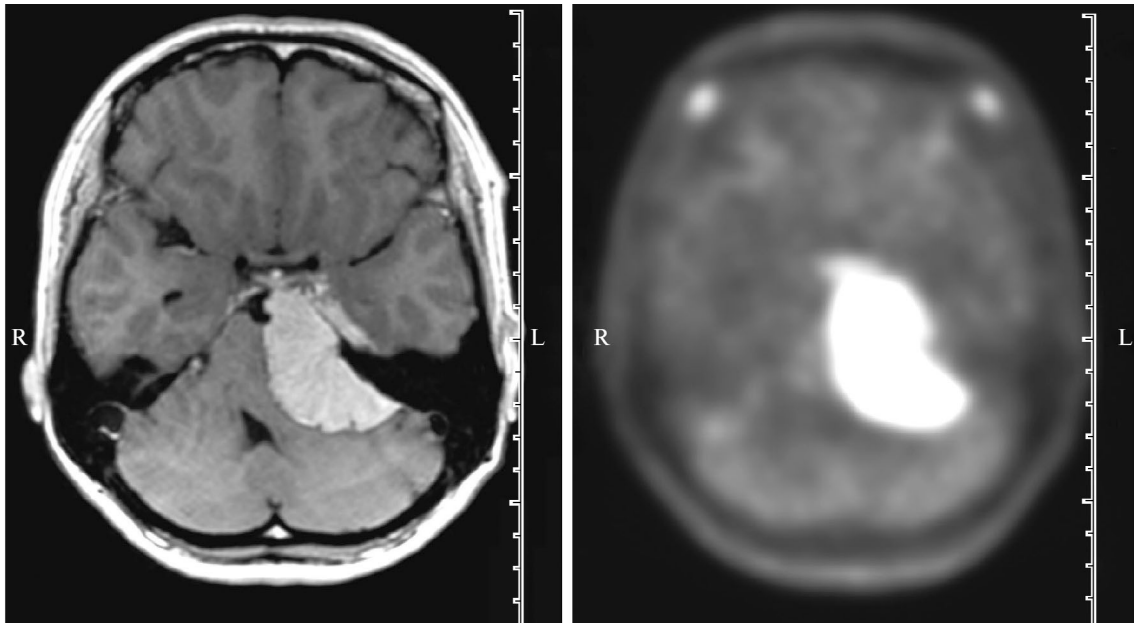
WHO grade 1 petroclival meningioma on MRI (left) and ^{11}C -methionine PET/CT (right). PET/CT reveals a high level of RT accumulation: 5.5.
